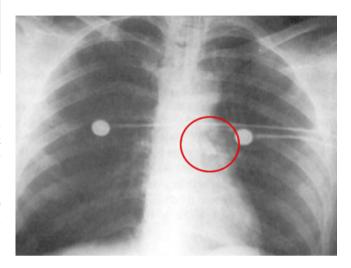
Tooth in lung. These can easily be missed on a plain film. With the newer adjustable digital images this is less likely
